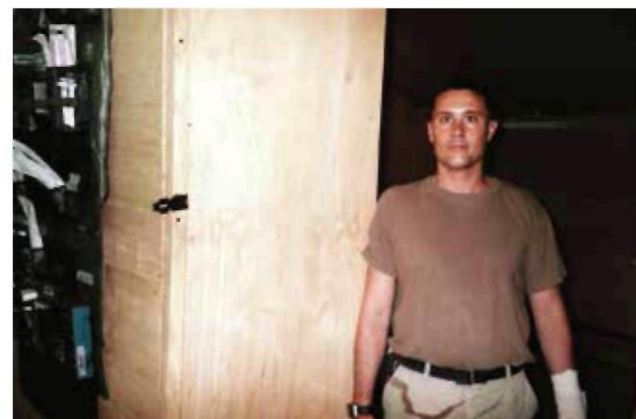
X-ray, FST tent in Camp Alpha (Iraq), 12 Dec 2003 (source: L. Kolarz)
